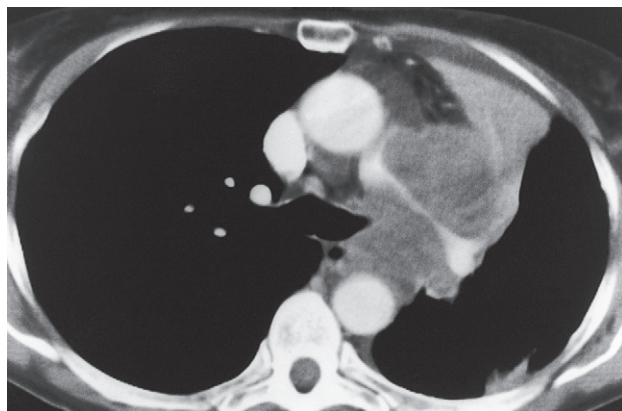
Mediastinal invasion. Contrast-enhanced CT showing extensive tumour in the mediastinum, compressing the left pulmonary artery and causing left upper lobe collapse. Ao, aorta; Br, bronchus; LPA, left pulmonary artery; SVC, superior vena cava.
